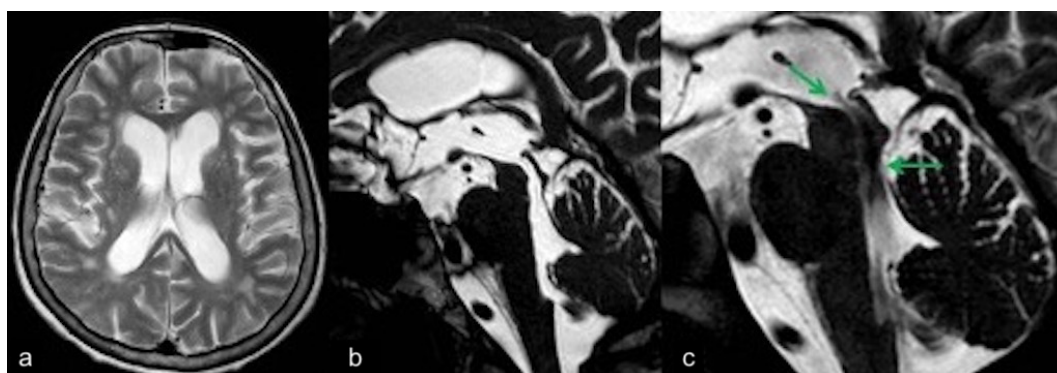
CSF Flow MRI image of a patient with iNPH. (a) T2-weighted image shows chronic ventriculomegaly in both lateral ventricles. (b) No obstruction is seen at the aqueductal level in the 3D Balanced Heavy T2 image obtained for morphological evaluation. (c) Flow void reflecting rapid CSF flow at the aqueductal level (arrows) in flow-sensitive T2 DRIVE image.
